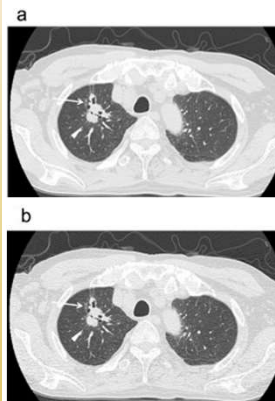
Image a is an example of a routine chest CT. Image b is a low-dose CT scan. The images are very similar to one another which emphasizes that there is not a huge difference in image quality between the two scans. (Kubo et al., 2016)
